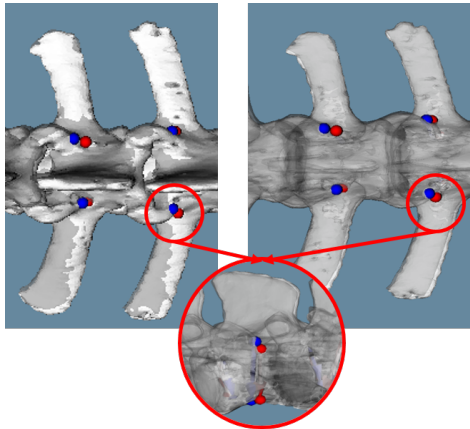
The registered post-operative CT model (grey) and drilled screw trajectories (red) overlaid with the pre-operative CT model (white) and surgical plans (blue).
